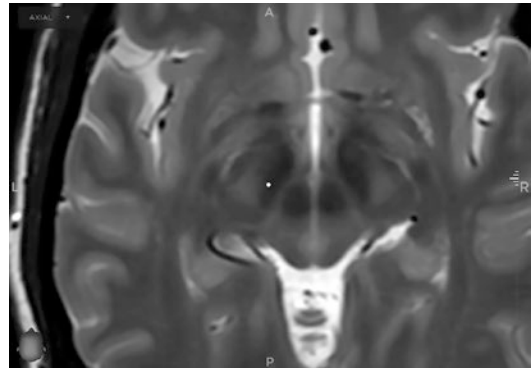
T2-weighted fast spin echo magnetic resonance imaging sequence obtained on a GE 3-Tesla scanner shows the subthalamic nucleus (STN) at the level of the red nucleus. Stereotactic coordinates of the left STN target (marker) are $(-10.75, -2.25, -4)$. (Used with permission from Barrow Neurological Institute, Phoenix, Arizona)
